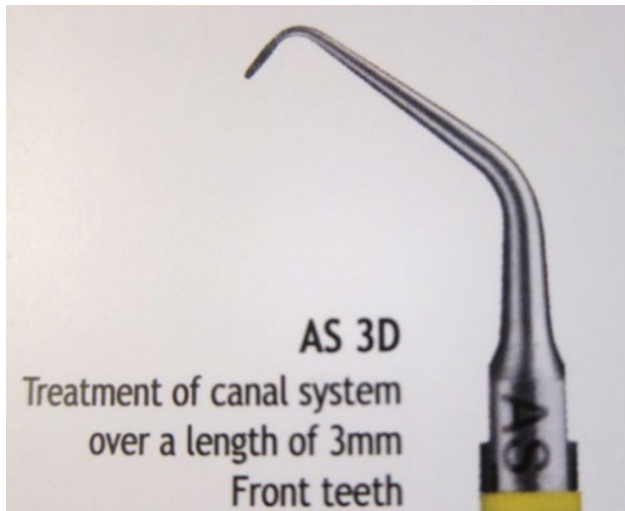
AS3D ultrasonic tip.
